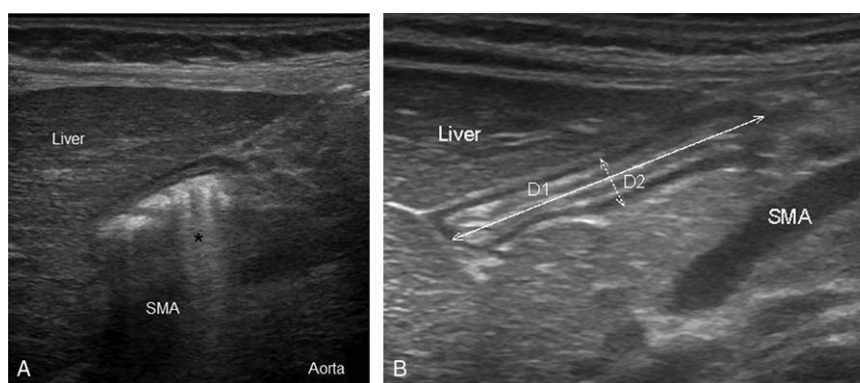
(A) Ultrasound images of gastric antrum after gastric insufflation showing acoustic shadows with comet-tail artifacts (asterisk). (B) Ultrasound images of the gastric antrum. On ultrasonography images, gastric antral area (GAA) was calculated from 2 orthogonal diameters of the antrum (D1 and D2). SMA=superior mesenteric artery.
